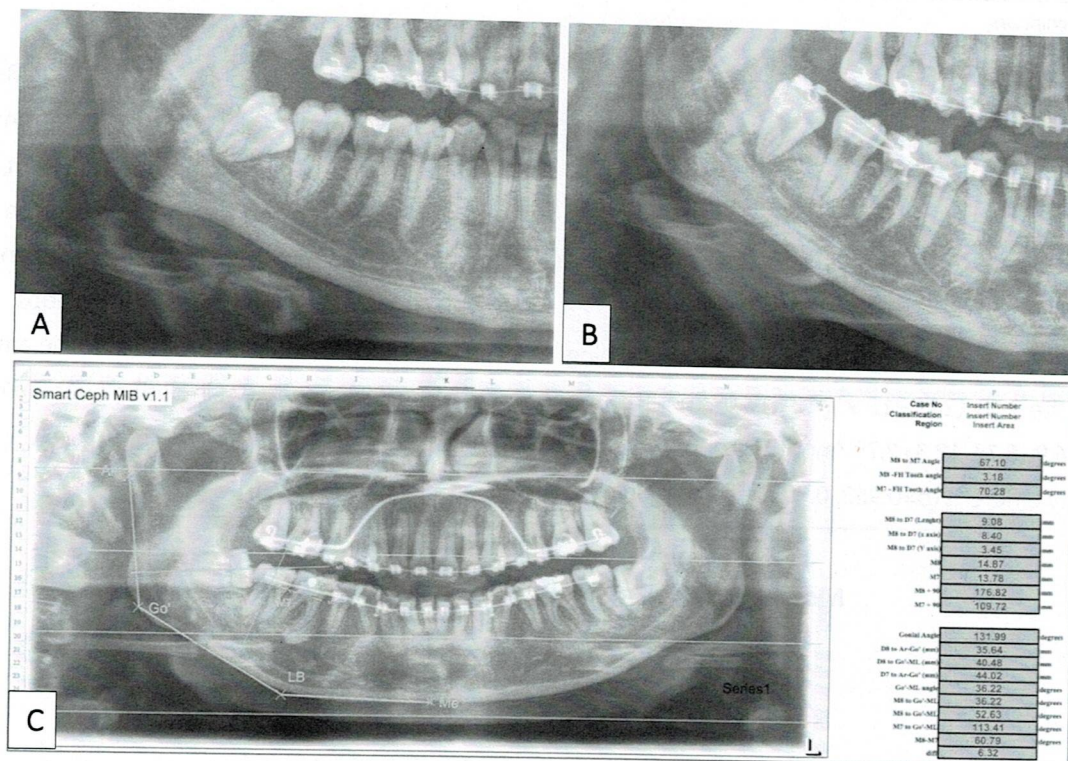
The assessment of changes in position and angulation of the MIBs and M7s using pre- and post-operative panoramic radiographs. A) before MIB uprighting, B) uprighted tooth after completed activation, and C) Smart'n Ceph MIB v1.1 software
